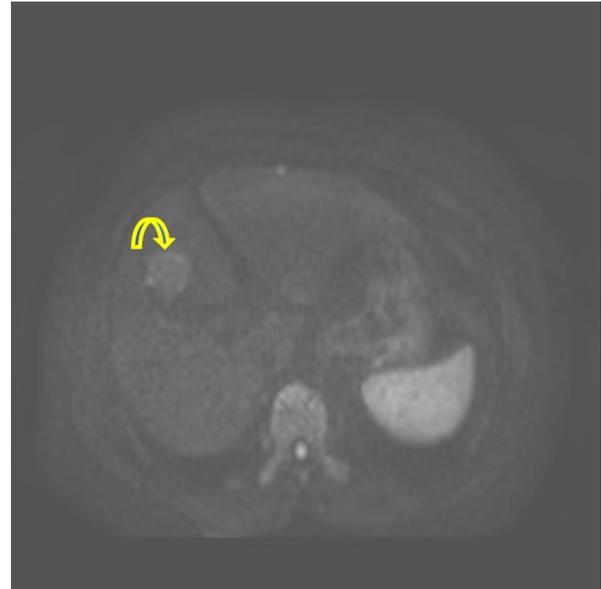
Magnetic resonance imaging (T2WI) of hepatitis B positive 50-years-old man. The arrow indicates mild hypersensitivity.
